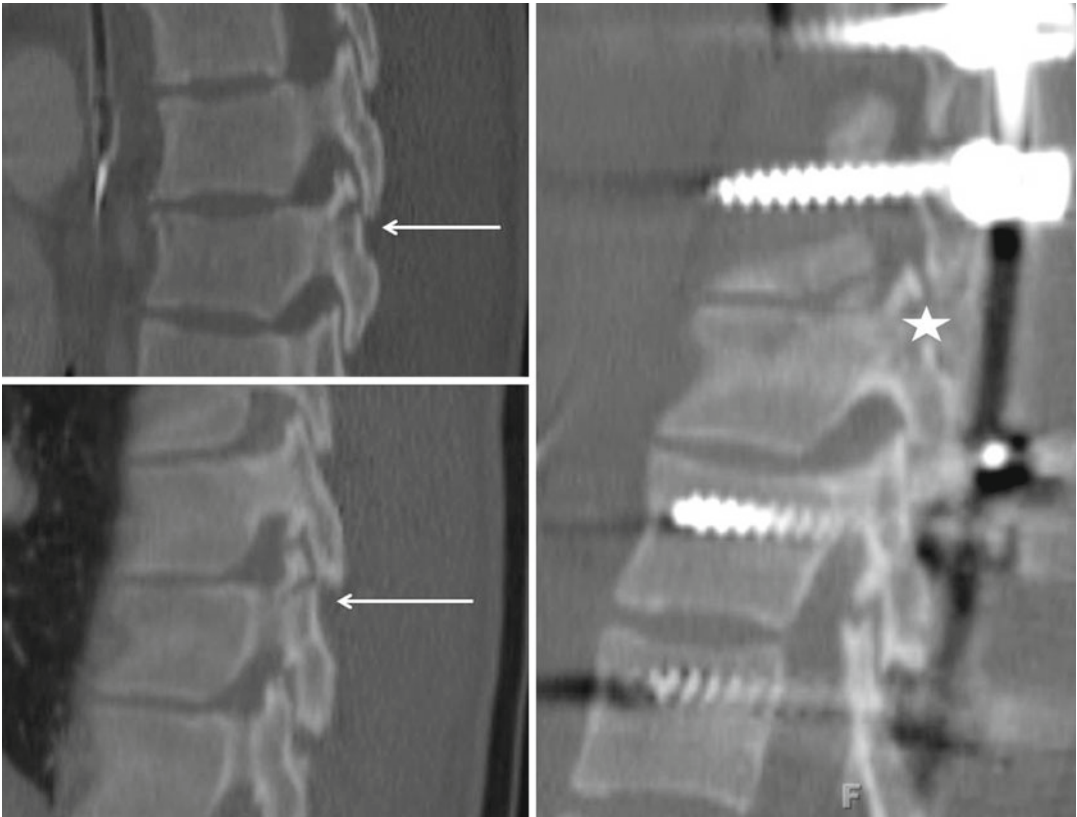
Left and right parasagittal computed tomography (CT) images show bilateral pars/facet fracture-subluxations (*arrow*) which add to three-column spinal
